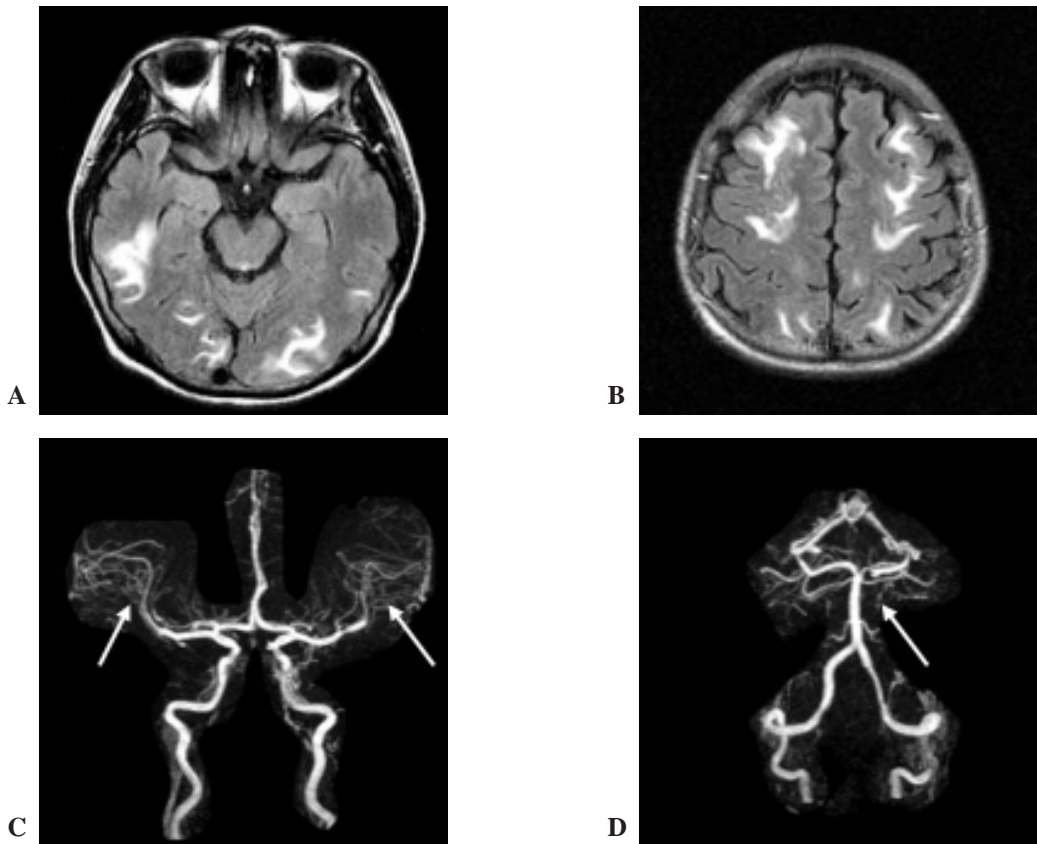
A-D MR images and MR angiography (MRA) of a 20-year-old female with underlying IgM nephropathy: A and B, Fluid-attenuated inversion recovery (FLAIR) MR images in axial plane show multifocal areas of high signal intensity involving the cortical gray and subcortical white matter of bilateral cerebral hemispheres C and D, MRA of the brain reveal multifocal moderate narrowing of the segmental branches of bilateral middle cerebral arteries and the left posterior cerebral artery with bead-like appearance (small arrows in C and D), compatible with vasculitis
